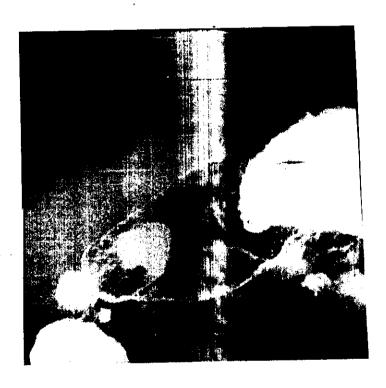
Double contrast radiography of inferior duodenal ulcer.
